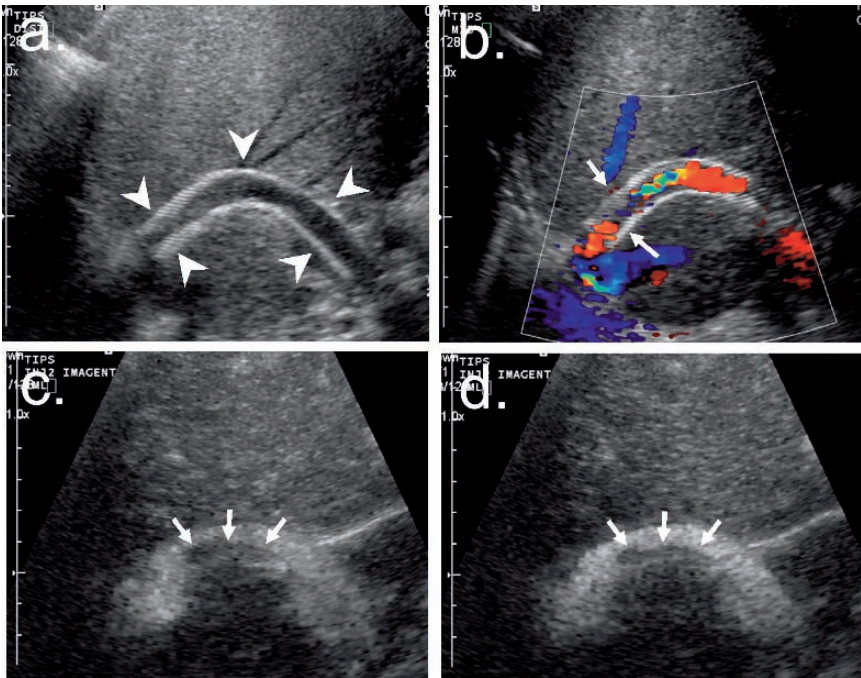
TIPS stent imaged with CEUS. a Conventional grayscale imaging showing the stent wall (arrowheads). Isoechoic intimal thickening cannot be visualized and stenoses are difficult to detect. b Color Doppler ultrasound image suggests the presence of narrowing (arrows). Assessment of stenoses is done by velocity measurement using duplex Doppler. c, d Grayscale contrast-enhanced ultrasound following the bolus injection of 1 ml of contrast clearly delineates the region of intimal thickening (arrows), location, and degree of stenosis.
